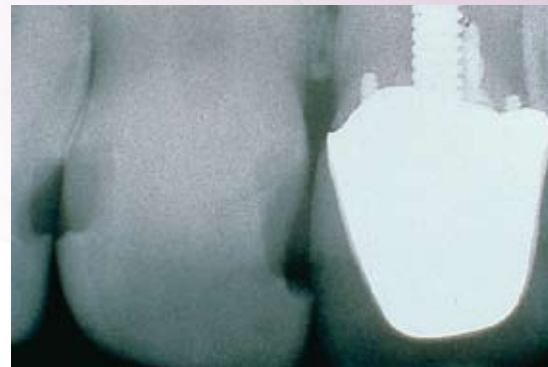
Initial radiograph. Note the square tooth shape, which creates thinner interproximal bone.
